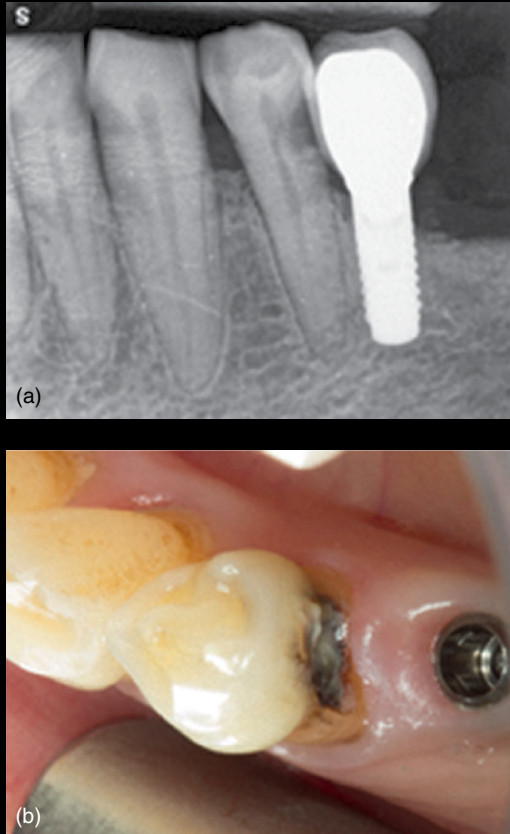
(a) Periapical radiograph of the LL4 demonstrating the extension and proximity to the pulp of the distal interproximal carious lesion. There appeared to be reactionary dentine in close relation to the carious lesion. No noticeable changes in the periapical tissues could be appreciated. (b) After removal of the implant-supported crown, the size of the carious lesion was assessed. The deep cavity was darkened and covered with soft plaque. It was also possible to visualise the undermined enamel in relation to the lesion.
